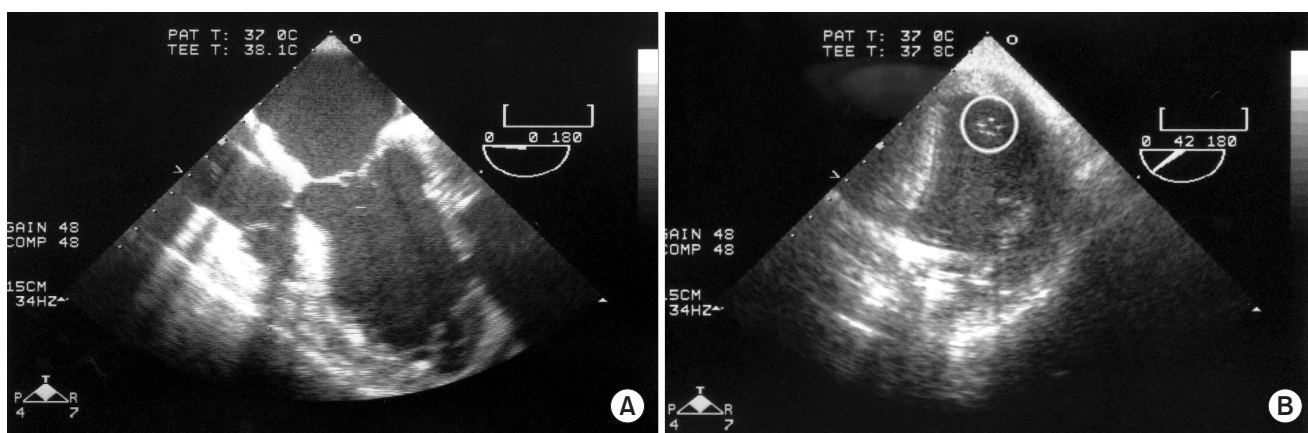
Transesophageal echocardiography performed during cardiopulmonary bypass weaning. (A) Four chamber view. Ineffective left ventricular contraction during the systolic phase was detected. At this time, even with high doses of inotropics and vasoconstrictors, the patient showed low cardiac output syndrome. We could not rule out mitral regurgitation as a cause for low cardiac output status; however, mitral valve closure seemed adequate. (B) LV short axis view. The stitched and reinforced endocardium is shown (white circle).
